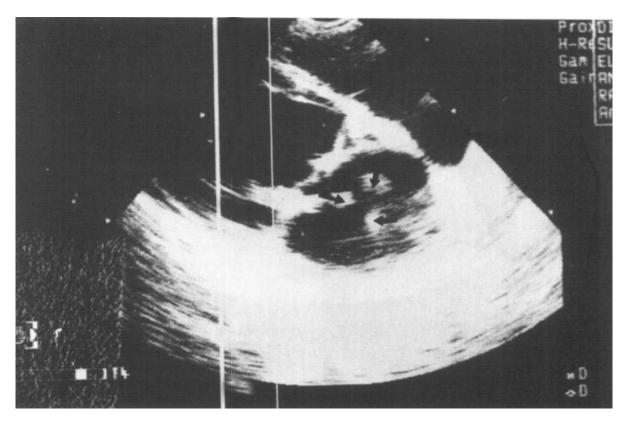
Second echocardiography showing three polypoid vegetations of the mitral valve, extending onto the left atrium (arrow)
